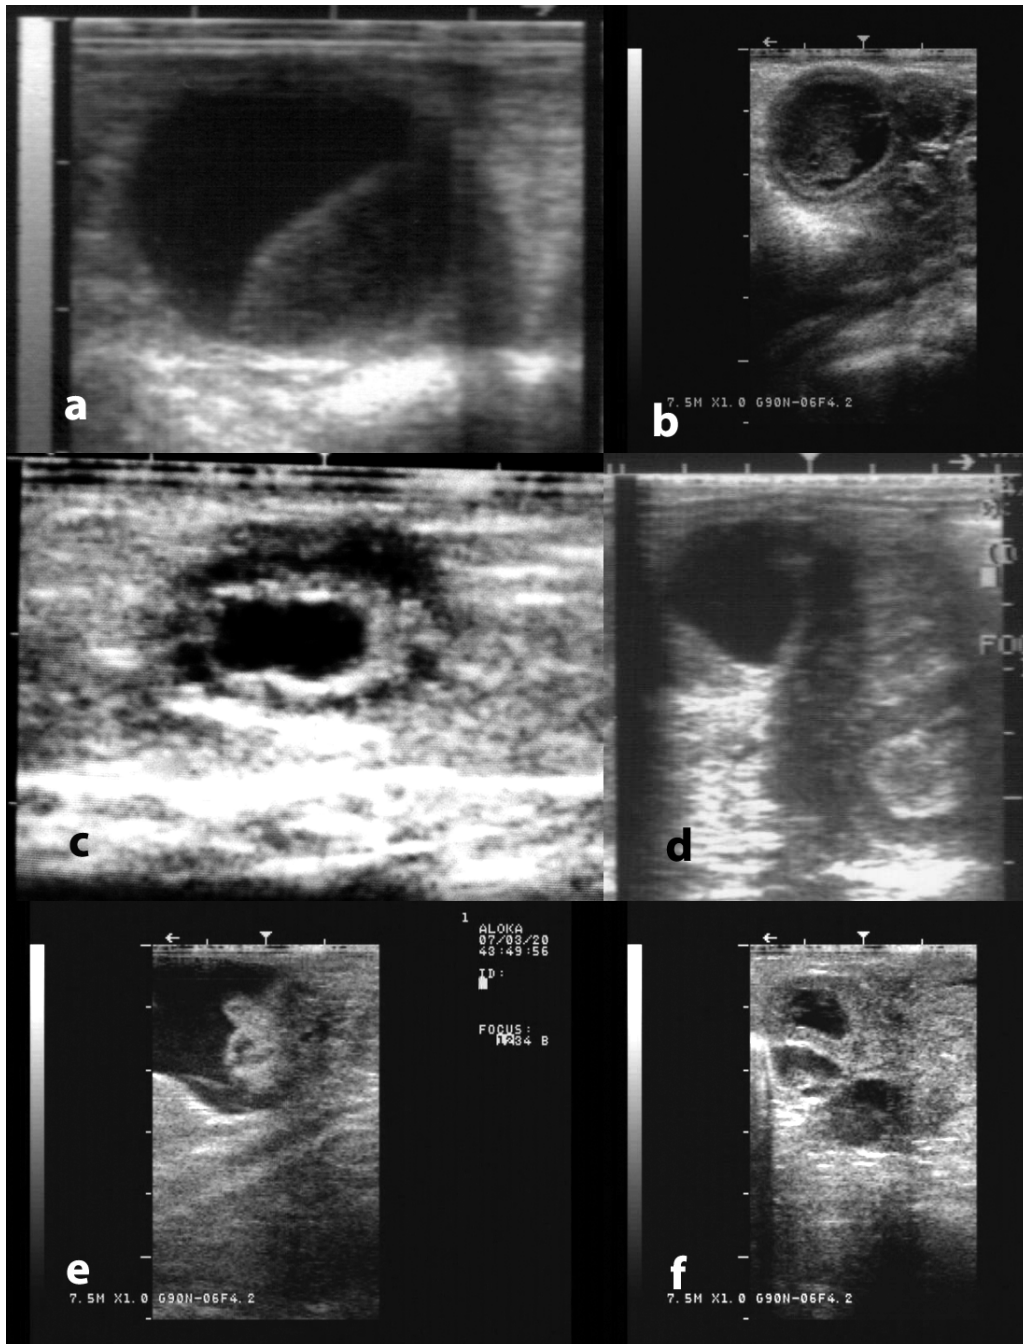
Ultrasonographic appearance of some ovarian and tubal disorders in camelids. a) Large anovulatory follicle, b) Luteinized/hemorrhagic anovulatory follicle, c) Cystic rete ovarii, d) Ovarian teratoma, e) Hydrobursitis, f) Hydrosalpinx.
